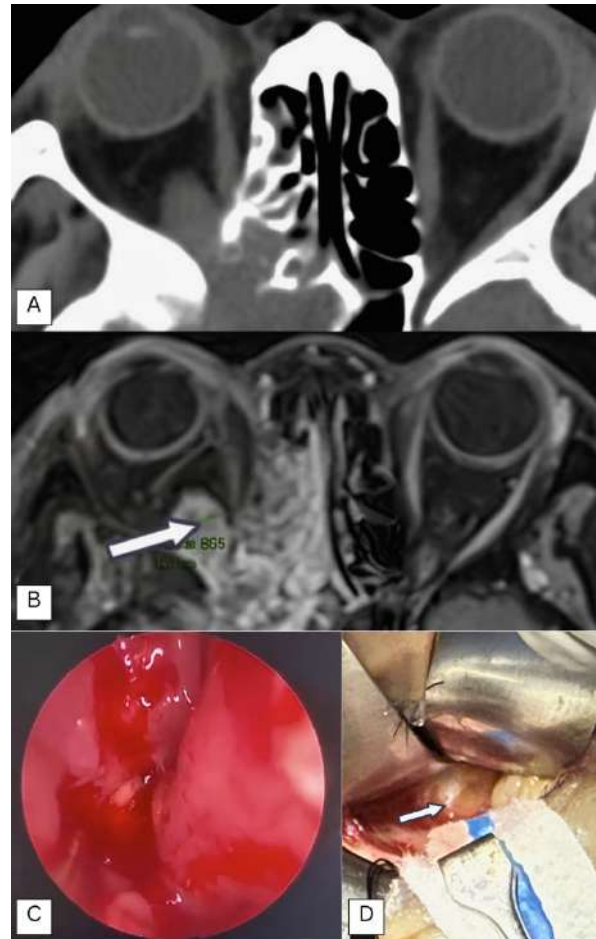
Day 29 of admission. Orbitotomy with incisional biopsy was performed at the site of the hyperdense signal on brain CT (A) and hyperintense signal on brain MRI (B), which radiologically mirrored the maxillary sinus lesion. Intraoperative endoscopy (C) primarily revealed inflammatory tissue without purulent discharge. A yellow fleshy mass was noted during orbitotomy, corresponding to the inflammatory tissue identified on CT and MRI scan (A, B).
